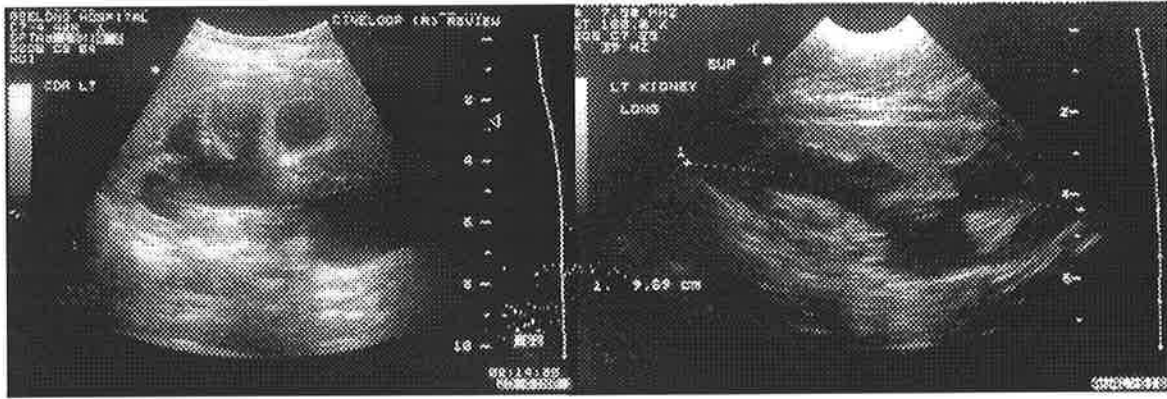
Ultrasound before and after final operation for Case 4.
